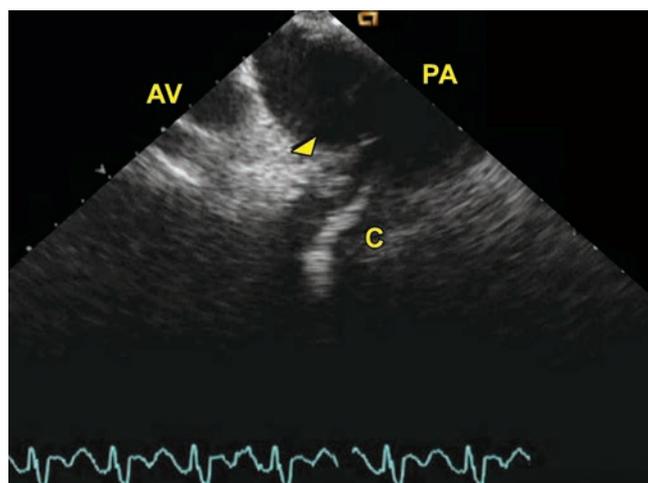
Multiplane two-dimensional transesophageal echocardiography in tetralogy of Fallot postrepair. Arrowhead shows a large mass like vegetation in the conduit (C) which is seen connected to the pulmonary artery (PA).  313. AV = aortic valve; AA = ascending aorta.
